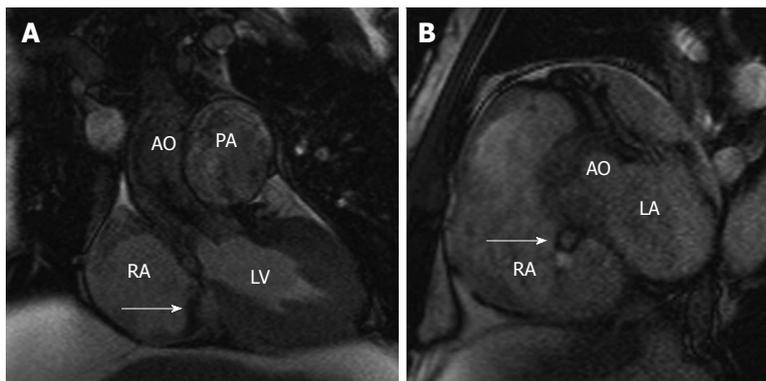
Aorta to right atrium fistula. A: Coronal state free precession (SSFP) magnetic resonance imaging (MRI) image in a patient with bicuspid aortic valve and infective endocarditis shows a fistulous communication between the aorta (AO) and the right atrium (RA), with a jet of abnormal flow (arrow) demonstrated between the aorta and the right atrium; B: Sagittal short axis SSFP MRI image in the same patient shows the fistulous connection (arrow) between the aorta and the right atrium. LA: Left atrium.
